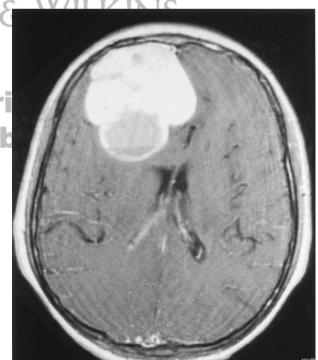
MRI (T1 weighted, after Gadolinium injection): parasagittal, polylobulated mass with broad base on the dura; intense contrast enhancement is present (Case 1).
